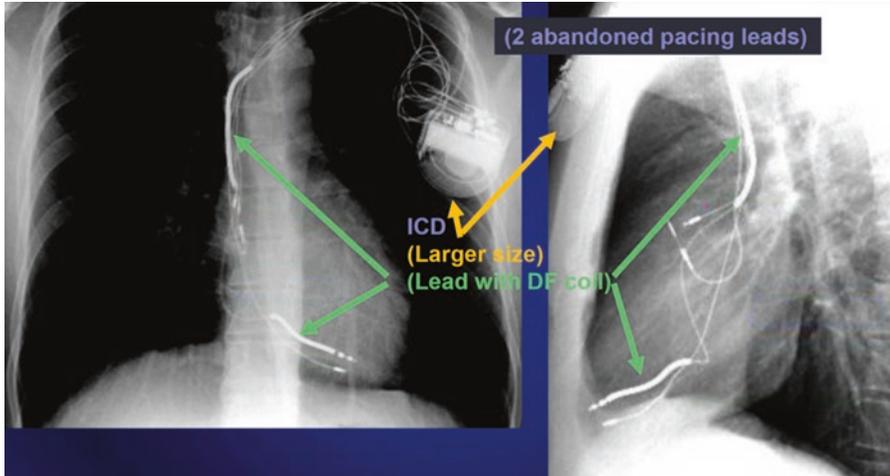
Anterior posterior and lateral chest x-ray showing an ICD
